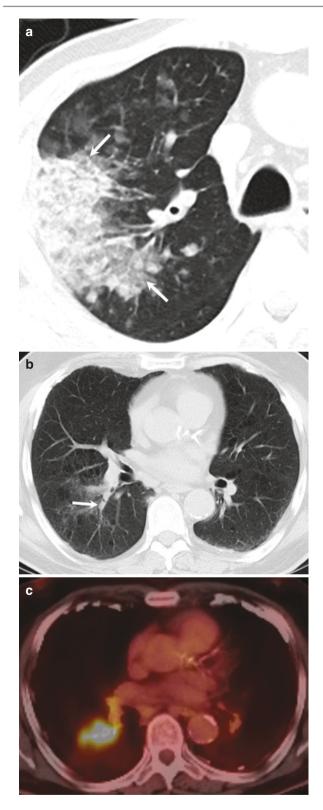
Tumor as persistent consolidation. (a) Axial CT thorax image in lung window shows a large area of consolidation and ground-glass opacity with air bronchogram in the right upper lobe (arrows). Tumor in another patient presenting as persistent bronchocele. (b, c) Axial CT and PET images show a endobronchial tumor as bronchocele (arrow)
